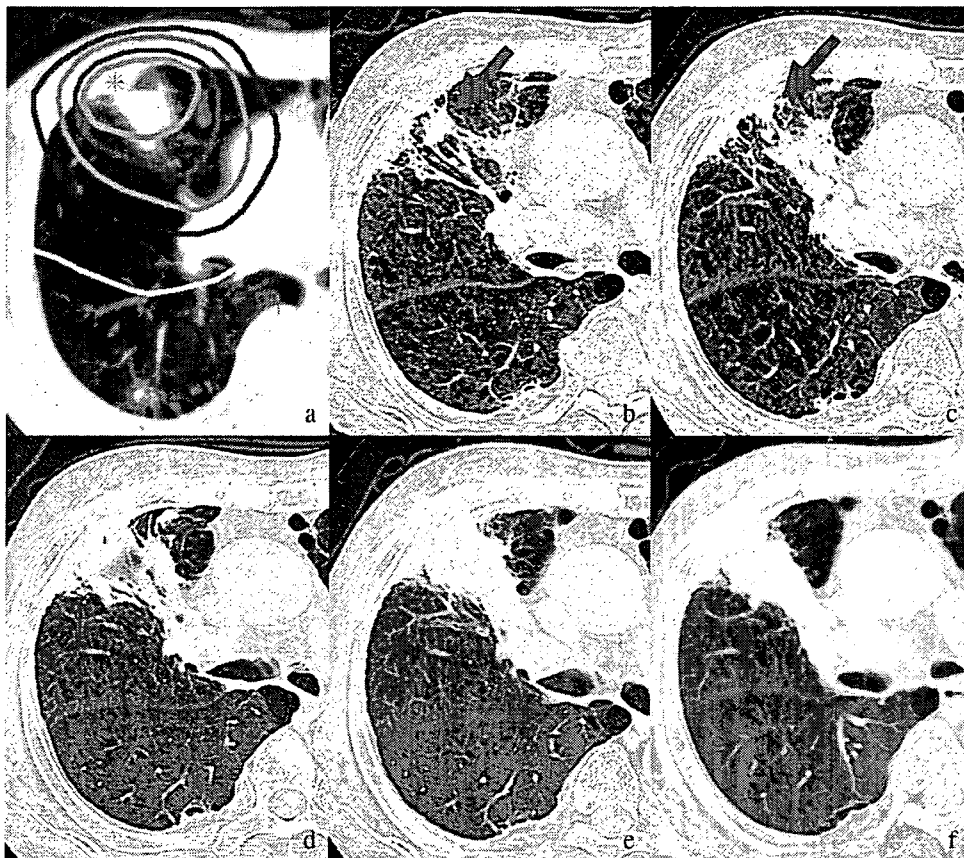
Transverse computed tomography (CT) images after hypofractionated stereotactic radiotherapy (HSRT) for highly suspected lung cancer in a 91-year-old man with a nodule in the right upper lobe. (a) Pre-HSRT image with isodose lines. The red line is the 80% isodose curve and corresponds to planning target volume (PTV). (b–f) Transverse CT images obtained at 13, 16, 19, 21, and 29 months after completion of HSRT. A linear shadow and bronchial traction appeared upstream from the tumor. Both gradually expanded into a solid opacity suggestive of obstructive pneumonia, radiation fibrosis, or hilar lymph node recurrence. However, the opacity was apparently stable between 21 and 29 months after HSRT. However, the tumor opacity at the periphery (arrow) gradually diminished. The solid lesion grew downward and obscured the diminished tumor opacity.
